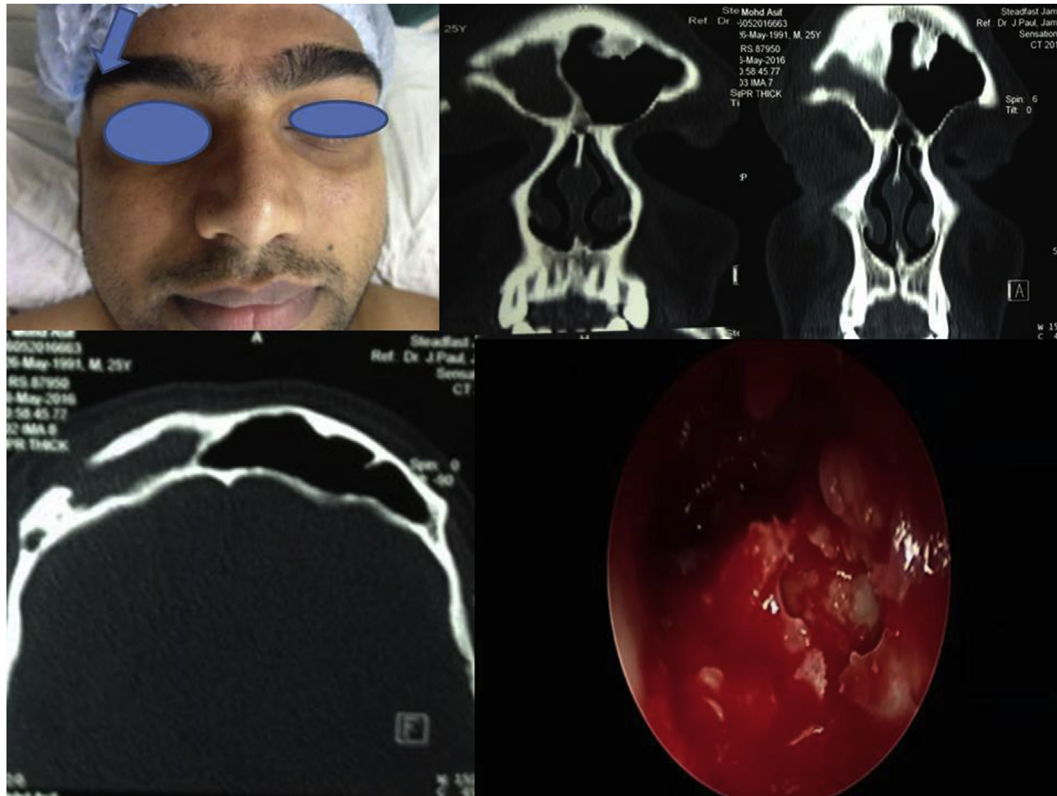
Showing preoperative swelling over right frontal region and preoperative coronal and axial CT scan showing soft tissue density in frontal sinus with erosion of frontal bone and intro-operative showing frontal sinus opening on right side.
